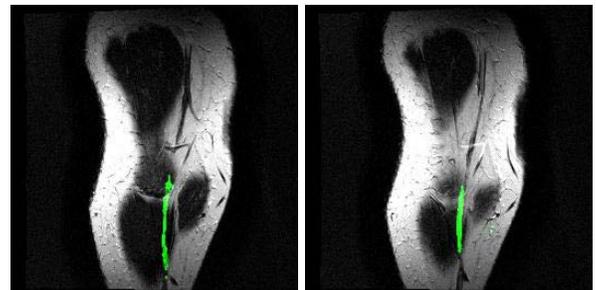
Fractional Anisotropic maps from DTI measurements demonstrates a linear region of increased anisotropy shown as a high signal intensity structure, along the anatomically identified sural cutaneous nerve. FA map is co-registered with the T2-weighted MRI.
